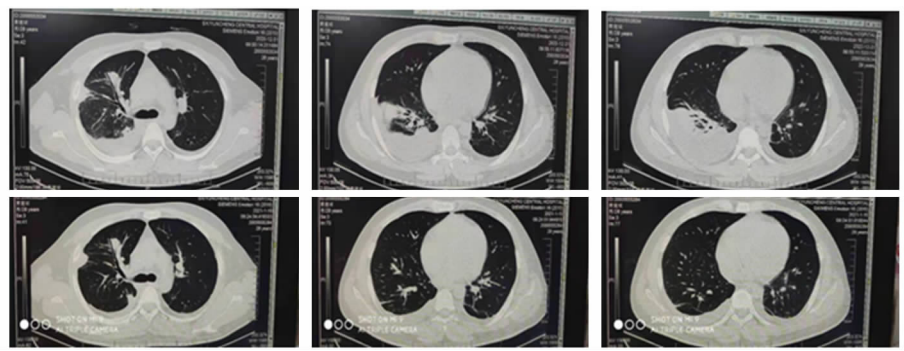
为患者急性髓系白血病 M5 化疗后肺部感染,两性霉素 B 治疗 6 天复查肺部 CT 效果明显
